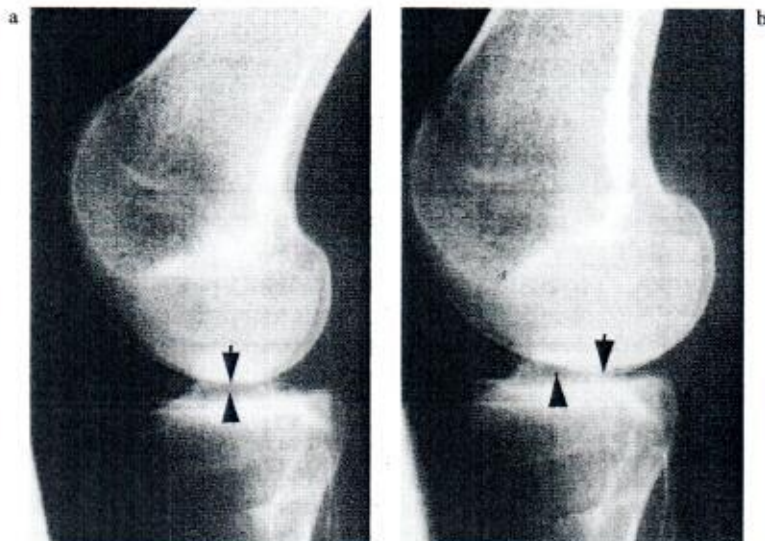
Lateral radiographic views of a 23-year-old female with rupture of the anterior cruciate ligament. Standing without loading (a) and at weight-bearing (b). Normally, in any degree of knee flexion, standing or supine, the lowest points of the articular surfaces of the femoral condyles (arrow) are sited at the center (arrowhead) of the tibial eminence (a). In weight-bearing (b) the tibia is displaced ventrally relative to the femur, indicating joint instability at every step of gait
